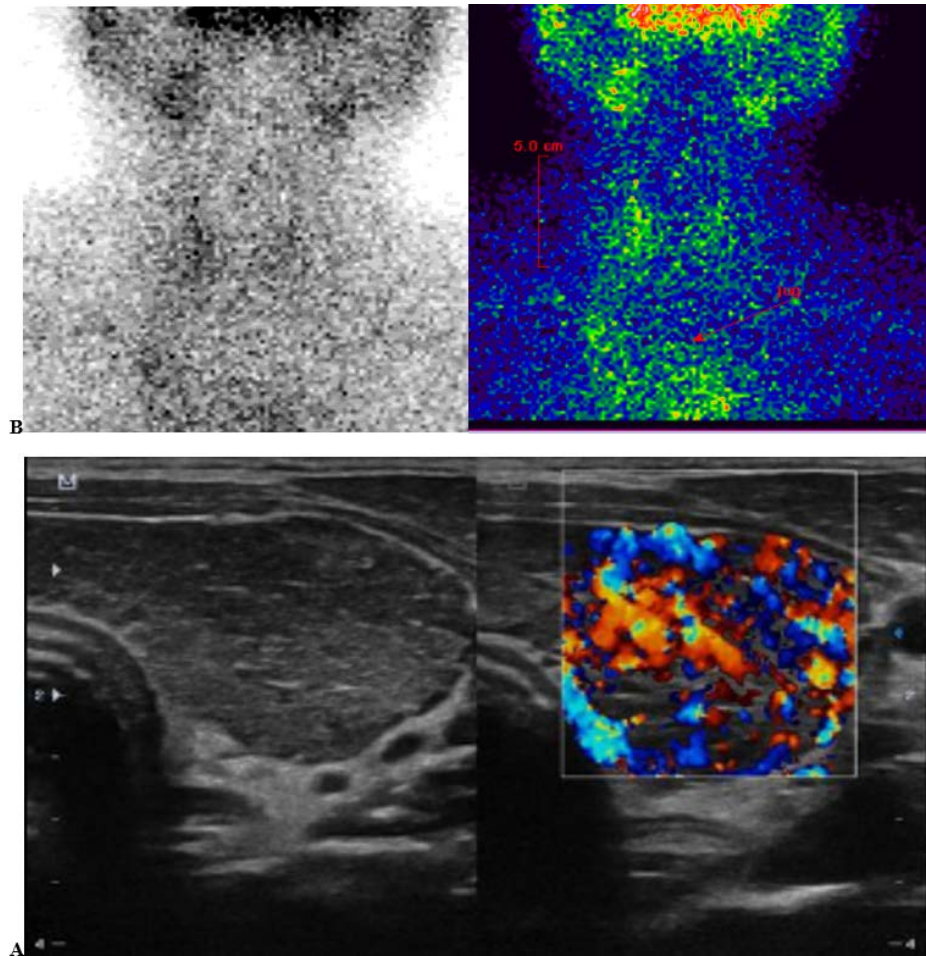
55-year-old woman. Clinic of thyrotoxicosis, laboratory picture of thyrotoxicosis, differential diagnosis between diffuse toxic goiter and Hashimoto's disease (thyroiditis), a) The ultrasound examination shows diffuse changes, the parenchyma of the thyroid gland has an inhomogeneous structure, with small reduced (low) echogenicity inclusions in it, a picture of thyrotoxicosis in the laboratory. b) Low uptake in the gland revealed a decreased inclusion rate of Tc99 0.2%.
